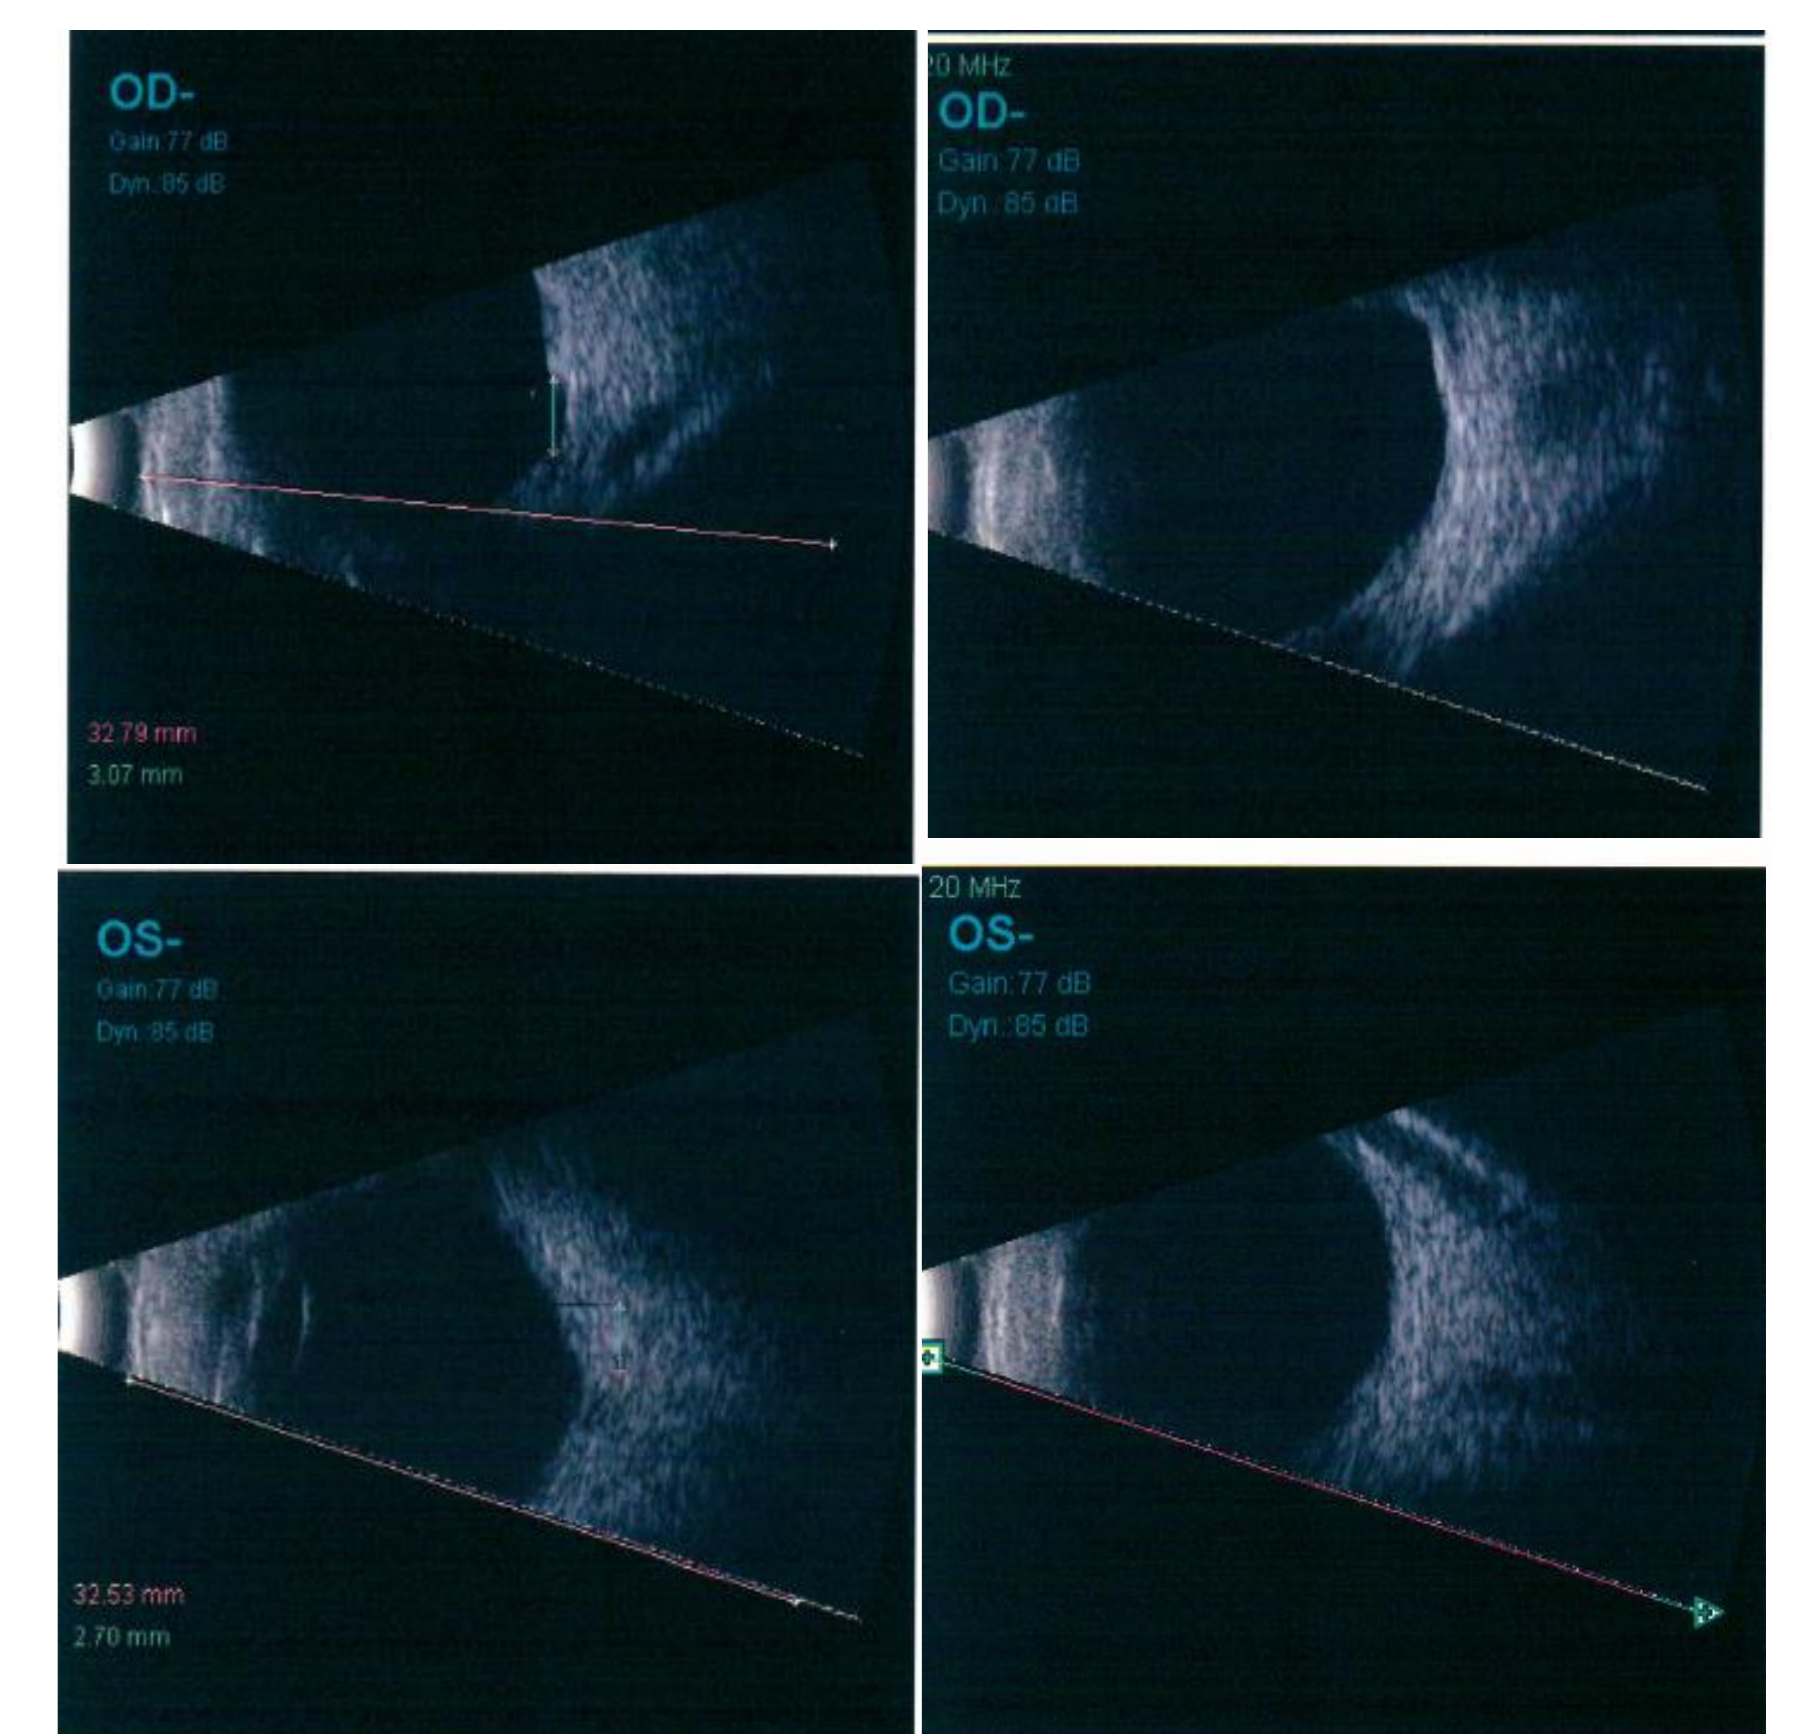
Ocular ultrasound mode B ODE
